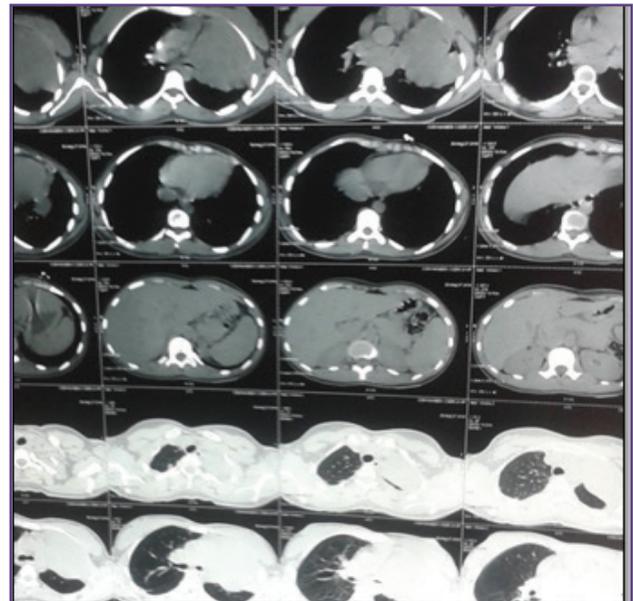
(CT scan) Heterogeneously Enhancing Mass In Left Upper Lobe.
